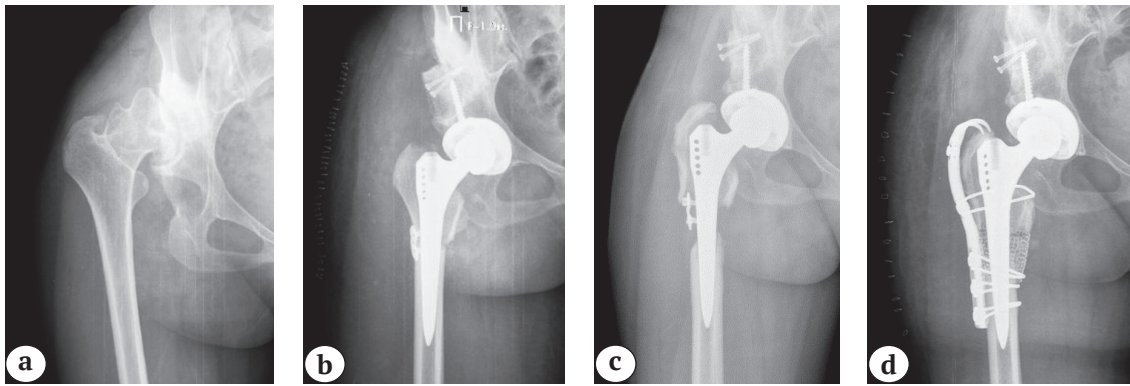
X-rays of female patient, 44 y.o., left hip dislocation;
